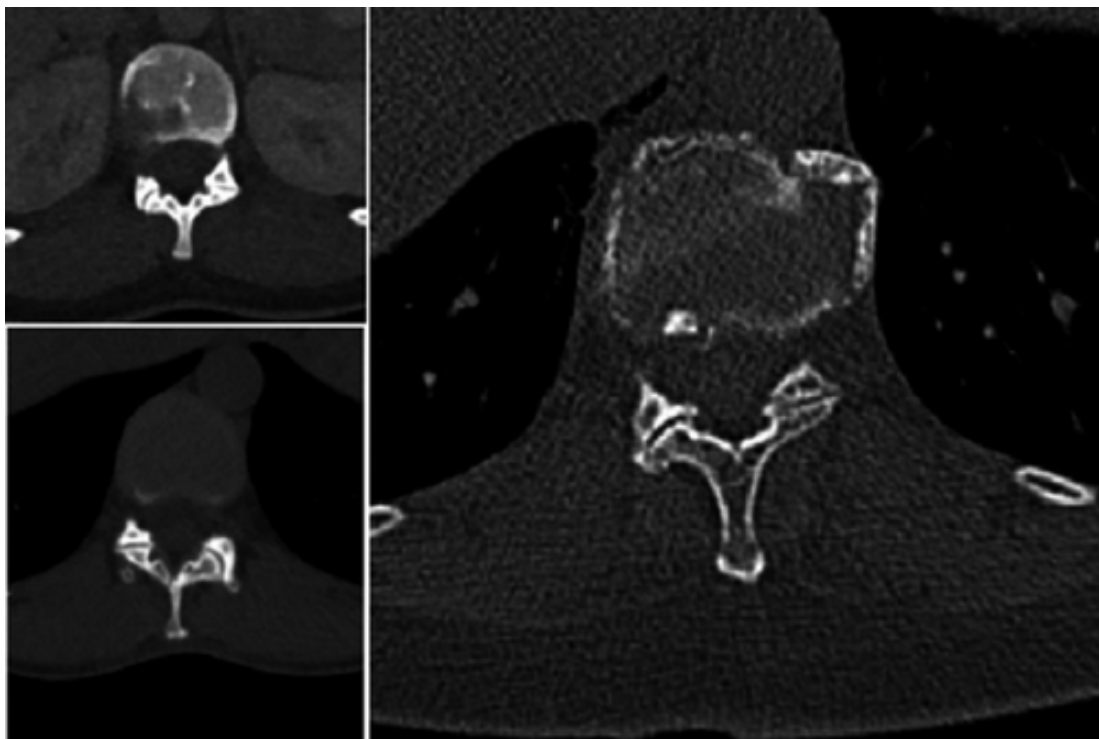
Axial CT Scans of TLTV
